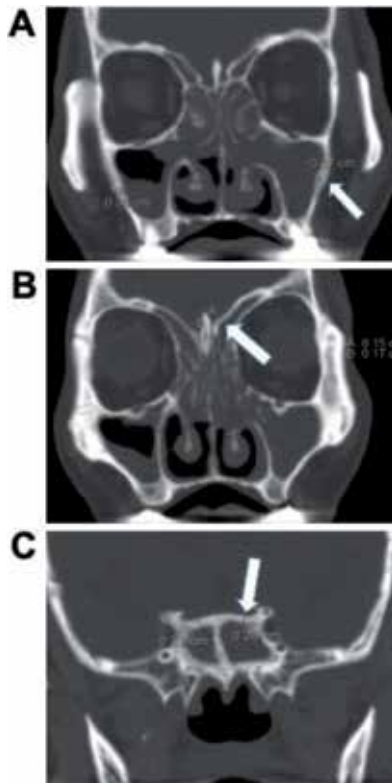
Representative sinus CT scan to measure sinus wall thickness. A 61-year-old male patient with recurrent CRS and status post two times of FESS; the figure shows the preoperative sinus CT image of the first FESS. (A) Maxillary sinus wall thickness is measured at the posterolateral region. The first cut is shown when the zygoma (white arrow) is separated from the maxillary sinus wall, measuring the thickest part. (B) Ethmoid sinus wall thickness is measured at the para-crista galli region around the lateral lamella, the thickest part (white arrow). (C) The sphenoid sinus wall thickness is measured at the first cut showing the anterior clinoid, the thickest part (white arrow).
